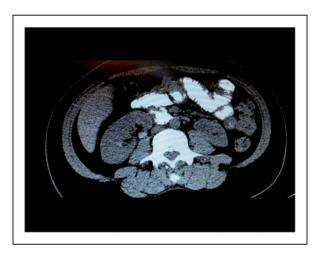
An abdominal CT, dilated loops of bowel.
